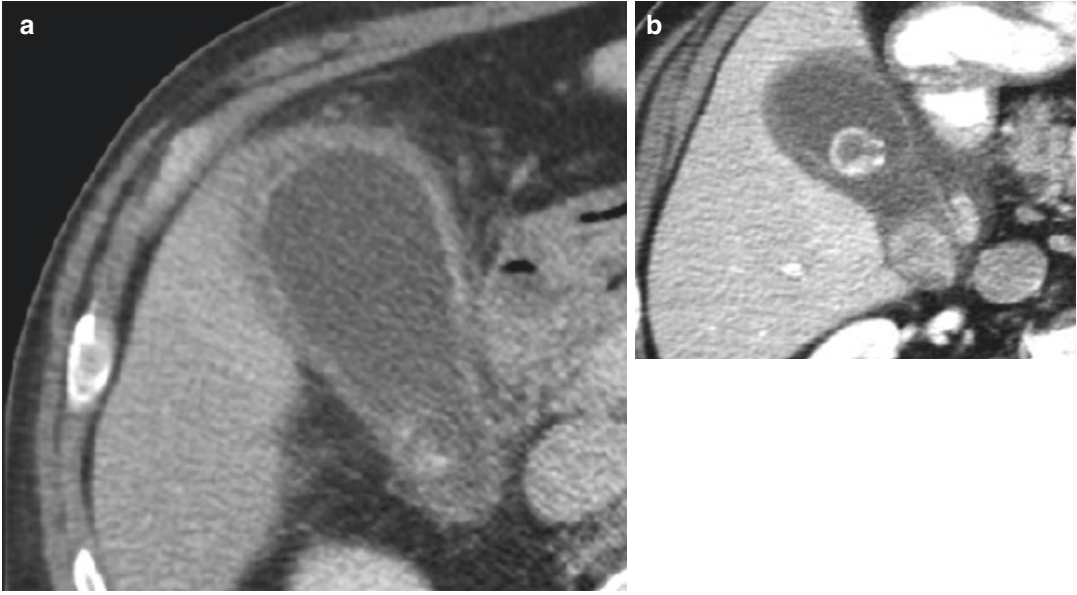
(a): CT scan, showing a distended gallbladder with impacted gallstone. (b): CT Scan, with distended gallbladder with impacted stone and another one in its lumen
